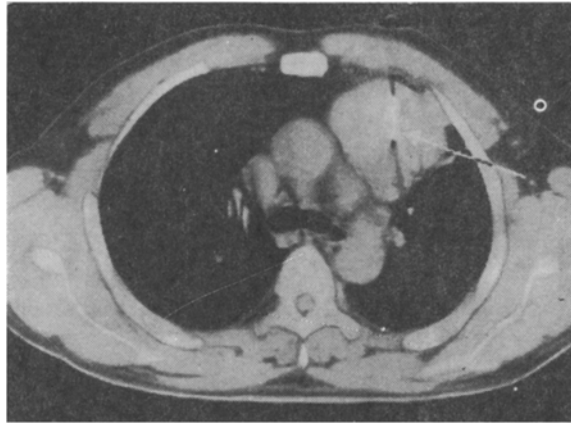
Aspiration biopsy with a wide-bore needle under CT control (arrow indicates needle in tumor).
